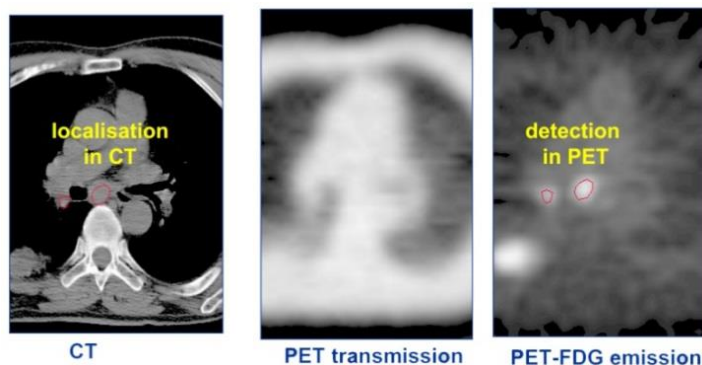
Example of thorax tumor staging from PET and CT [46].
